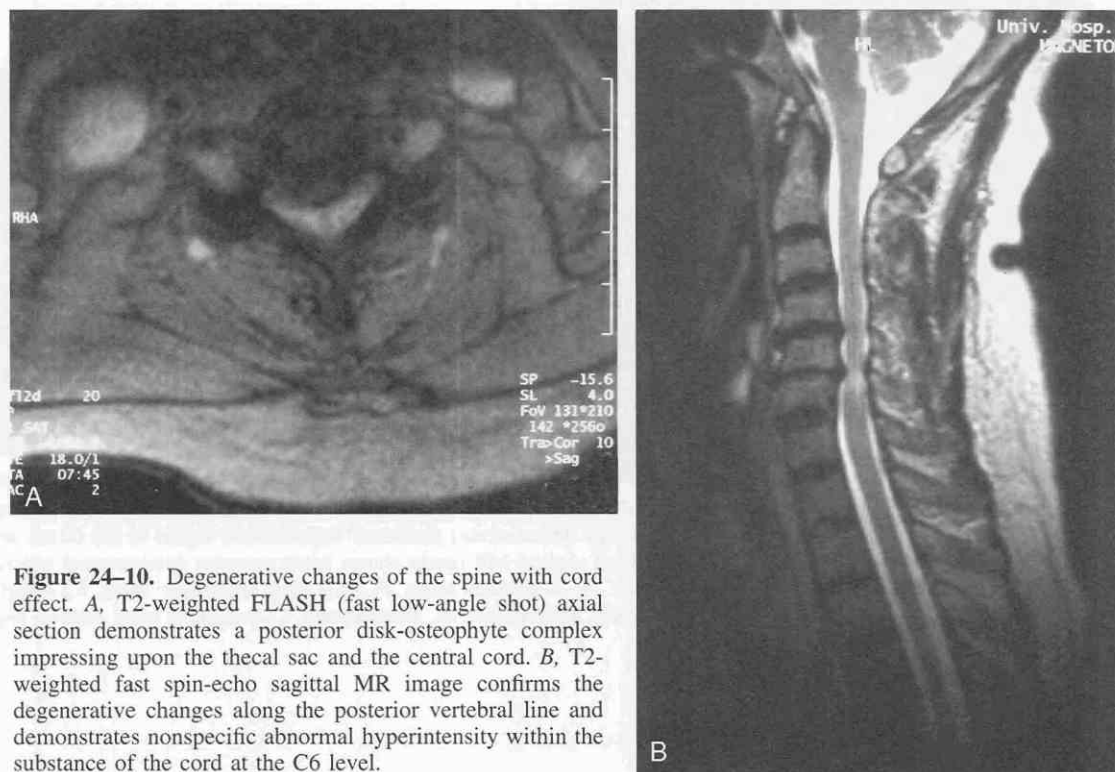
Degenerative changes of the spine with cord effect. A, T2-weighted FLASH (fast low-angle shot) axial section demonstrates a posterior disk-osteophyte complex impressing upon the thecal sac and the central cord. B, T2-weighted fast spin-echo sagittal MR image confirms the degenerative changes along the posterior vertebral line and demonstrates nonspecific abnormal hyperintensity within the substance of the cord at the C6 level.
